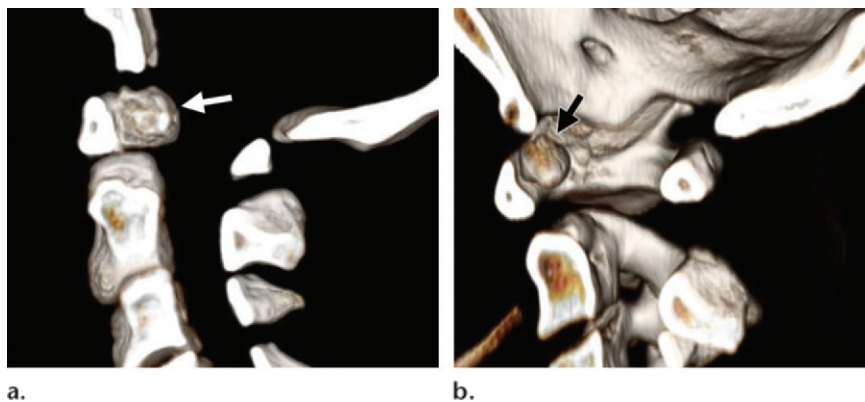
Old odontoid fracture compared with os odontoideum. (a) Half-space slab volume-rendered CT image of a 61-year-old patient struck with a brick in the back of the head shows an old unfused odontoid fracture with a short gap between the odontoid and the C2 body, which maintains the basic shape of the dens (arrow). (b) Half-space slab volume-rendered CT image of a 9-year-old patient shows an os odontoideum (arrow). Note the large gap between the os odontoideum and the axis body.
